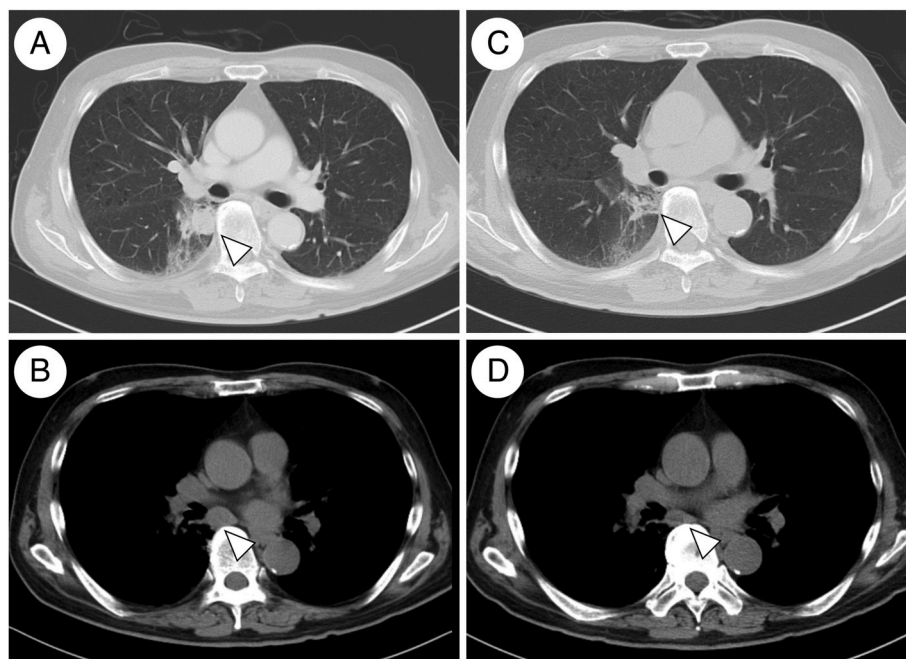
Chest CT images on admission (A, B) and 15 days after one course of pembrolizumab (C, D). A, B: Chest CT on admission shows an irregular lung nodule in the right lower lobe and lymphadenopathy in the mediastinum (arrowheads). C, D: After one course of pembrolizumab, the lung nodule and mediastinal lymph nodes decreased in size.
